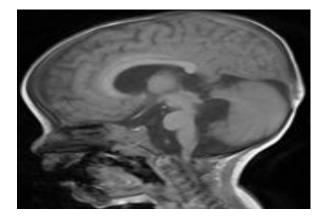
T1W sagittal MRI image showing evidence of vermian agenesis
